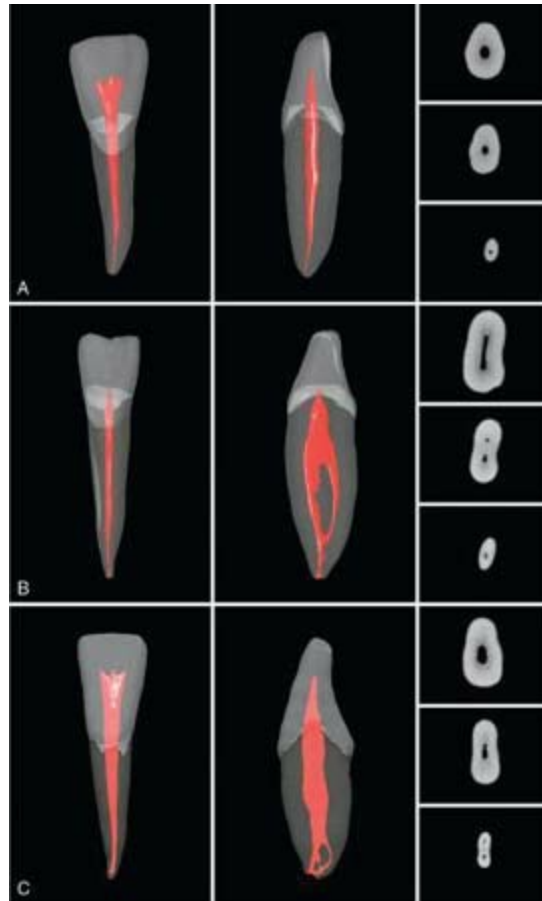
μ CT scans of mandibular central incisors. A, Common anatomic presentation. B, Central incisor with two canals. C, Central incisor with an apical delta. All teeth are shown from both a buccal (vestibular) and a proximal perspective, along with the cross-sectional anatomy at the coronal, middle, and apical levels. (See Video 7.12 online at the Expert Consult site for rotational views of these teeth.)
